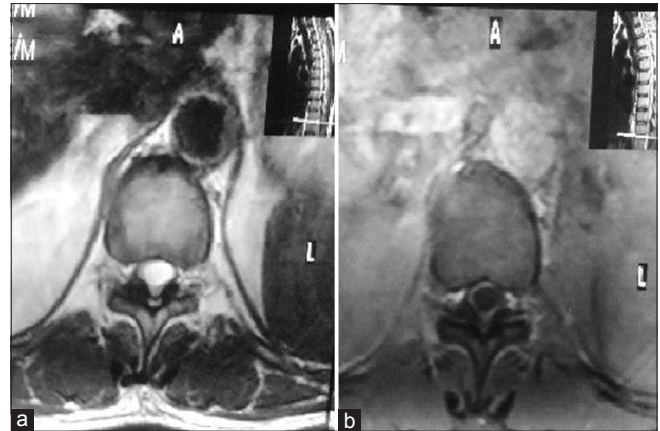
(a) Contrast axial magnetic resonance image showing cystic intramedullary lesion which is hypointense on T1W1 and hyperintense on T2W1 with thin peripheral ring enhancement (b)
